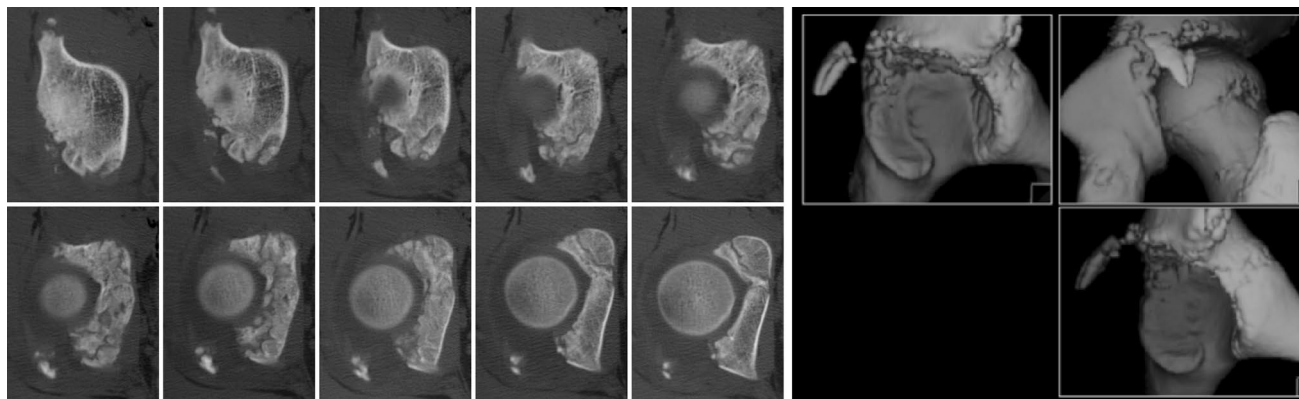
Preoperative CT-scan, axial view and 3D reconstruction, showing acetabular fracture with displacement of a bone fragment of the posterior wall and involvement of the posterior part of the transverse growth line. The acetabulum is retroverted
